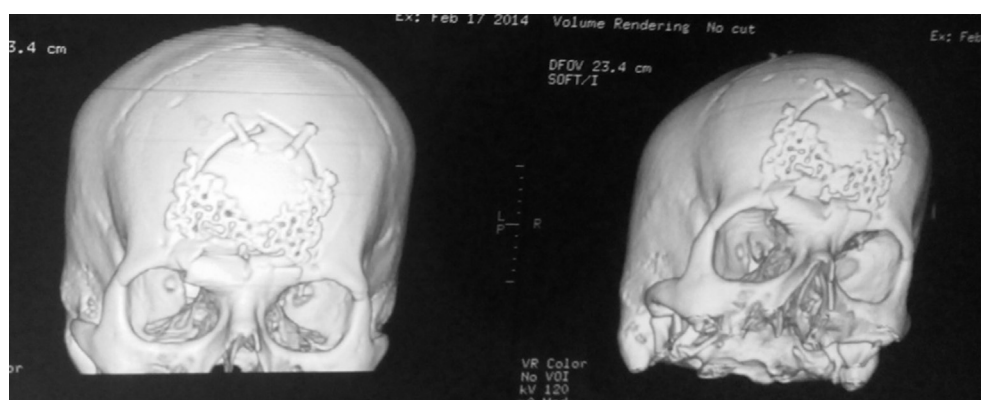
Post-operative 3-D CT reconstruction of the skull showing the repaired compound fracture in the mid-Frontal region with native bone fragments, mini-plates, titanium mesh resulting in a stable and cosmetically acceptable construct, the patient had an underlying EDH and superior Saggital sinus injury.
